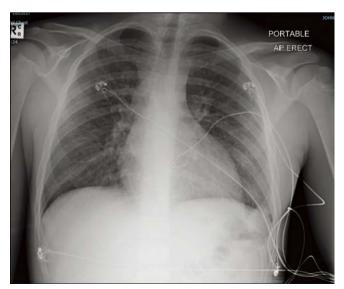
Chest radiograph on day 3 of admission
